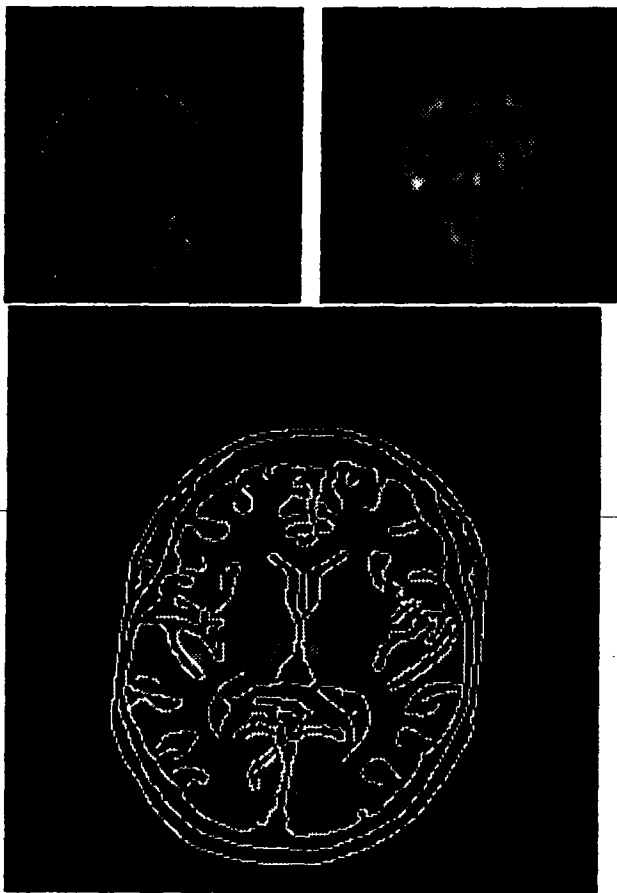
A potential based method allows the registration of an MRI image (top left) with a NMI image of the head (top right). Interpolated cross section of the registered 3D MRI is computed, and its edges are shown superimposed on the NMI images (bottom). Images are courtesy of Jael Travers, from the Cyceron Center in Caen, France. (Courtesy of G. Malandain and J.M. Rocchisani).
